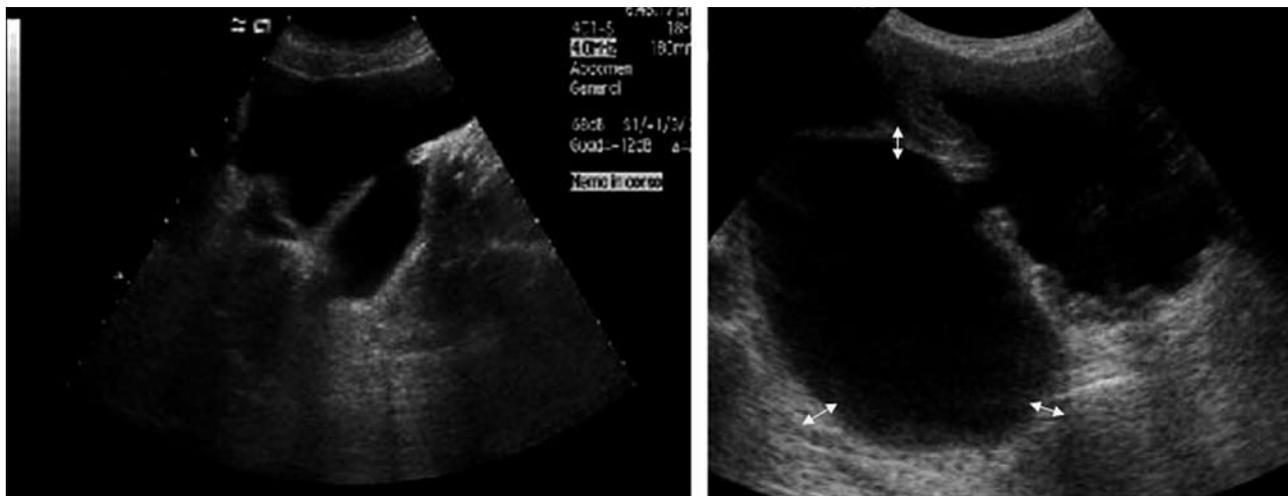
Ultrasound scan of the bladder diverticulum
